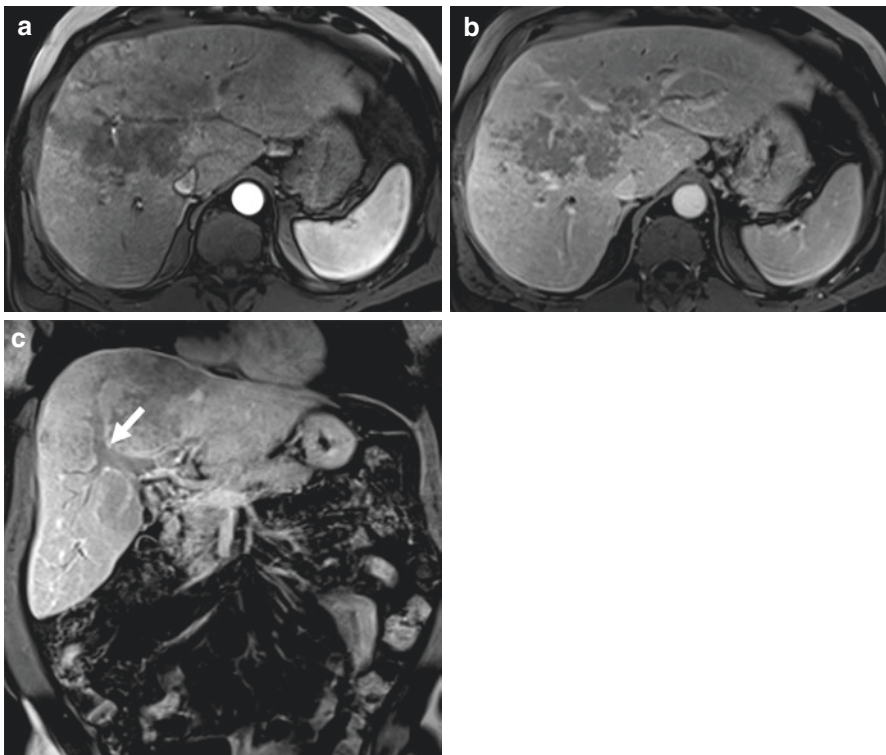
Periductal-infiltrative cholangiocarcinoma. Axial T1-weighted post-contrast image (a) in the arterial phase demonstrates ill-defined infiltrative tumor centered in the right liver lobe with extension to the periphery. Axial (b) and coronal (c) portal phase images demonstrate progressive enhancement of the tumor. Note extensive tumor invasion of the portal vein (arrow in c)
